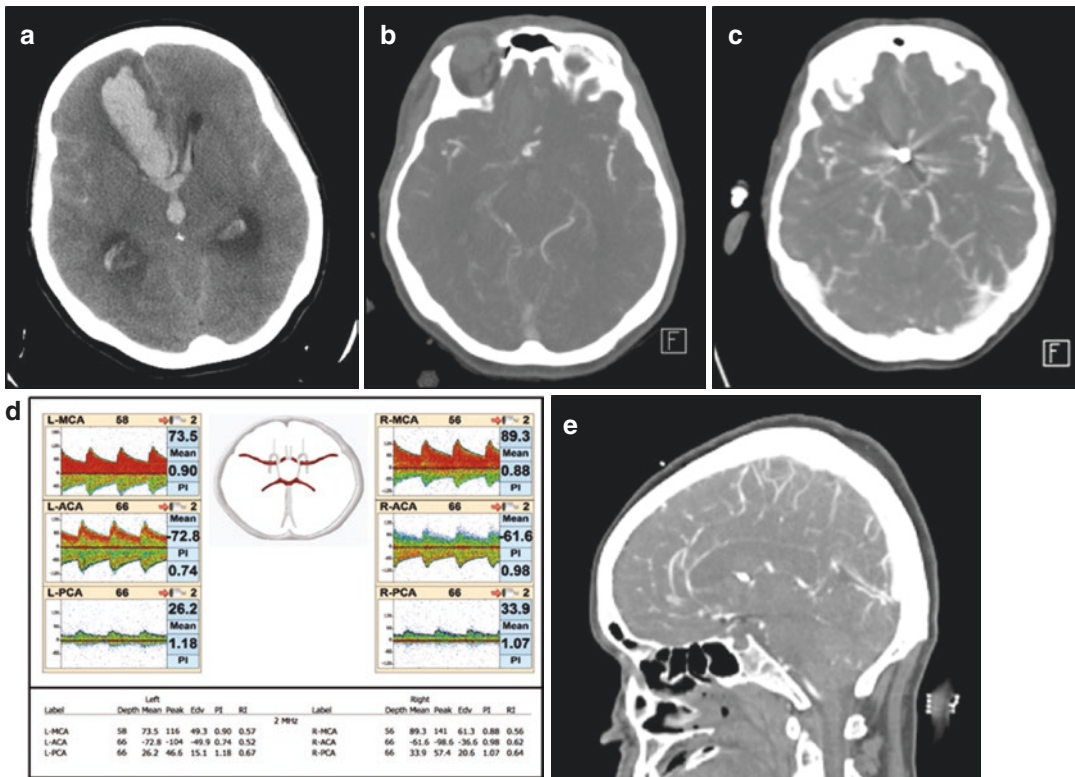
Right frontal lobe intraparenchymal hemorrhage from anterior communicating artery aneurysm rupture followed by transcranial Doppler (TCD) for vasospasm, finally resulting in right anterior cerebral artery (ACA) distribution infarct. A 53-year-old female found down in her car on the side of the road. Computed tomography (CT) head (a) showed a large right frontal intraparenchymal hemorrhage, intraventricular hemorrhage, hydrocephalus, and diffuse subarachnoid hemorrhage (SAH). CT angiogram (b) showed a 6-mm bilobed ruptured anterior communicating artery aneurysm. This was endovascularly coiled the next day (c). TCD done a day later showed normal peak (systolic) and mean flow velocity, waveform, and direction in the anterior cerebral
